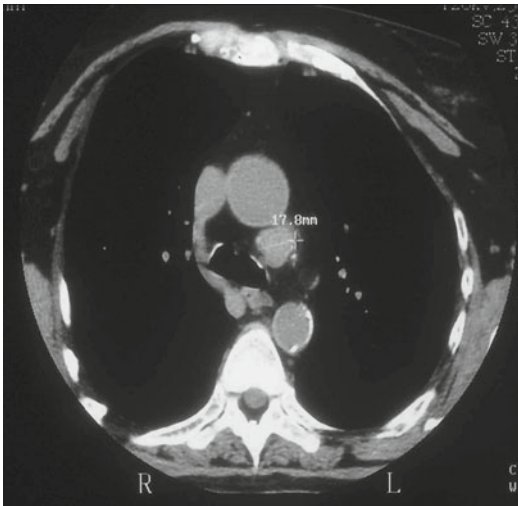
Computed tomography image of a supernumerary ectopic abnormal parathyroid gland located in the aorto-pulmonary window. This patient was reoperated on for persistent hyperparathyroidism. At initial surgery, four normal glands were identified in the neck
